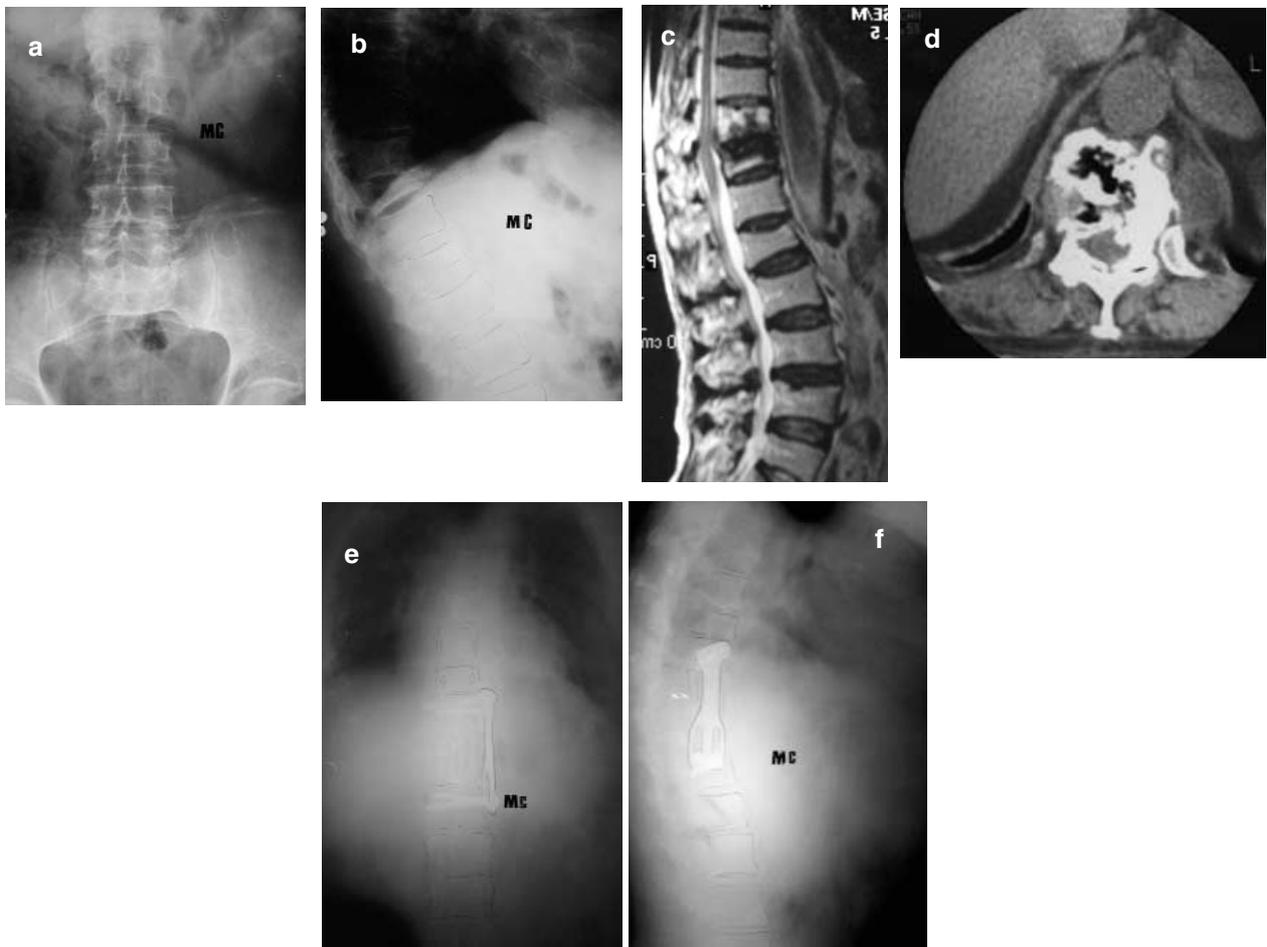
Preoperative AP (a) and lateral (b) graphies and sagittal (c), axial (d) MR images of the patient (MG) treated with anterior radical debridement, anterior strut grafting and anterior Z-plate instrumentation. Postoperative A-P (e) and lateral (f) of the patient is seen in the figure.
